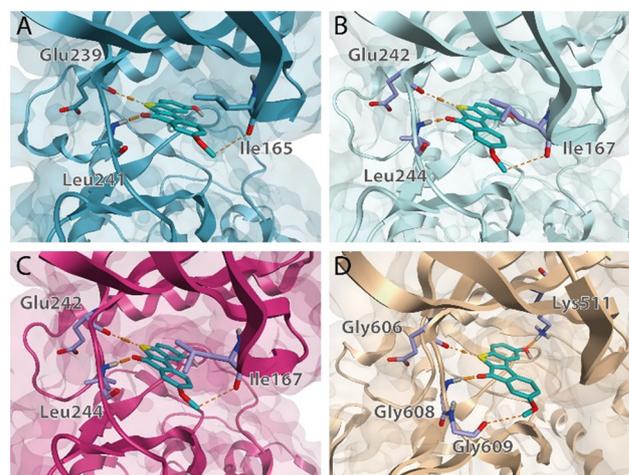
Top docking poses of compound 4k within the X-ray structures of DYRK1A (PDB: 5AIK) in dark blue (A), CLK1 (PDB: 6RAA) in cyan-grey (B), CLK4 (PDB: 6FYV) in magenta (C) and haspin (PDB: 3IQ7) in wheat (D). The kinases are shown as ribbon with their surfaces in transparency. The results showed marked homology in the stabilization of compound 4k within the 4 proteins. Residues engaged in stabilizing interactions are highlighted in orange. Haspin kinase exhibits a slightly different binding system.
